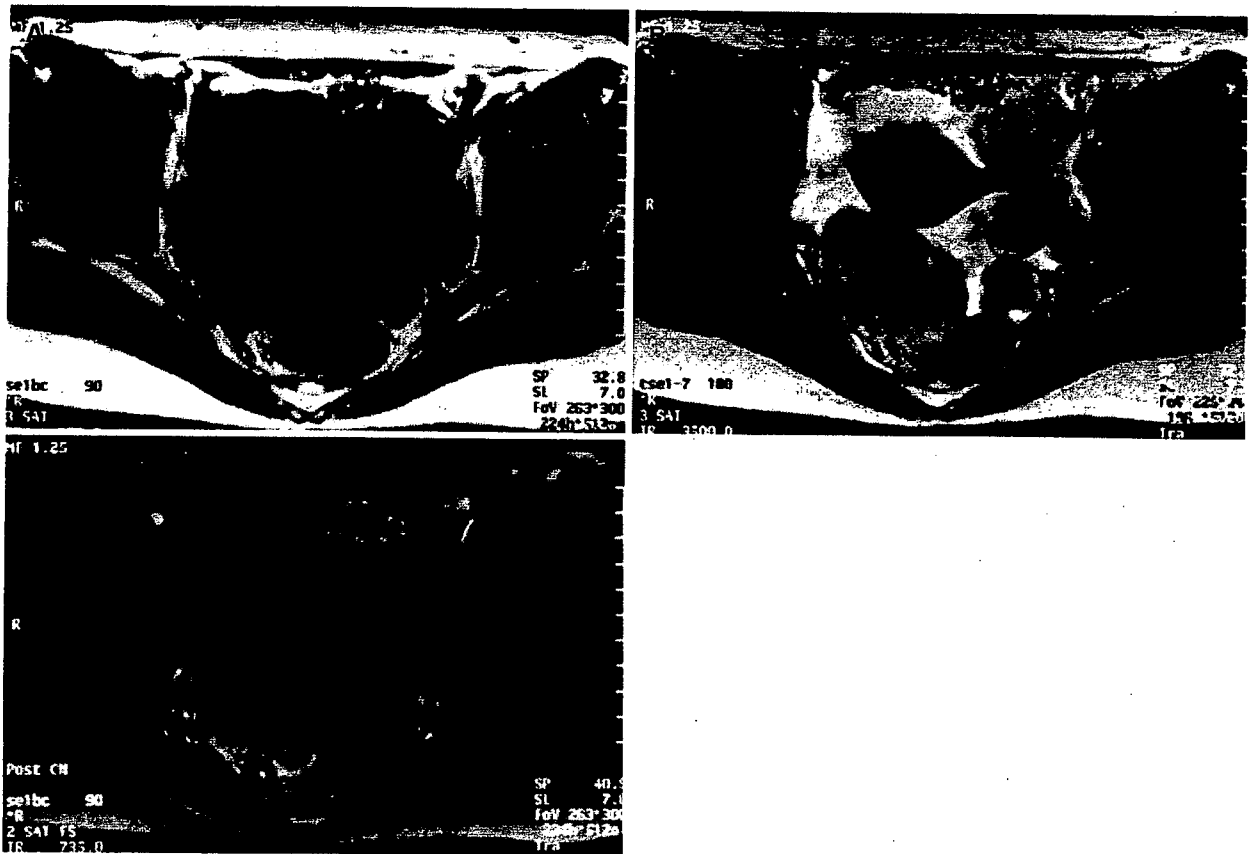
A 37-year-old woman of pT3cN0M0 (grade 3) without endometrioma. A Axial spin-echo T1-weighted MR image (600/12) shows diffuse isointense dissemination along the left uterine round ligament, Douglas pouch, mesenterium, and peritoneum. B Axial turbo spin-echo T2-weighted MR image (3500/96) shows diffuse
